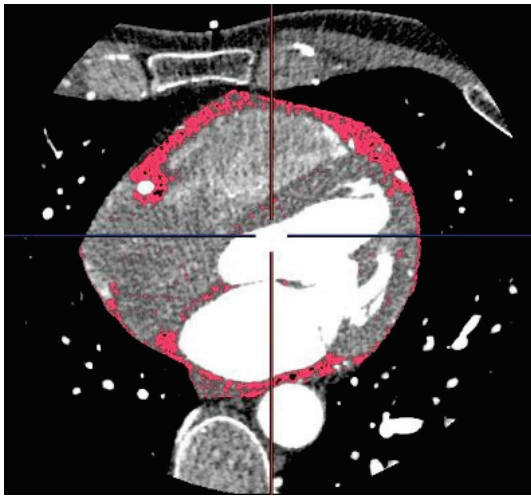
CT scan of a 49-year-old male patient depicting the epicardial adipose tissue (red) immediately internal to the pericardium.
